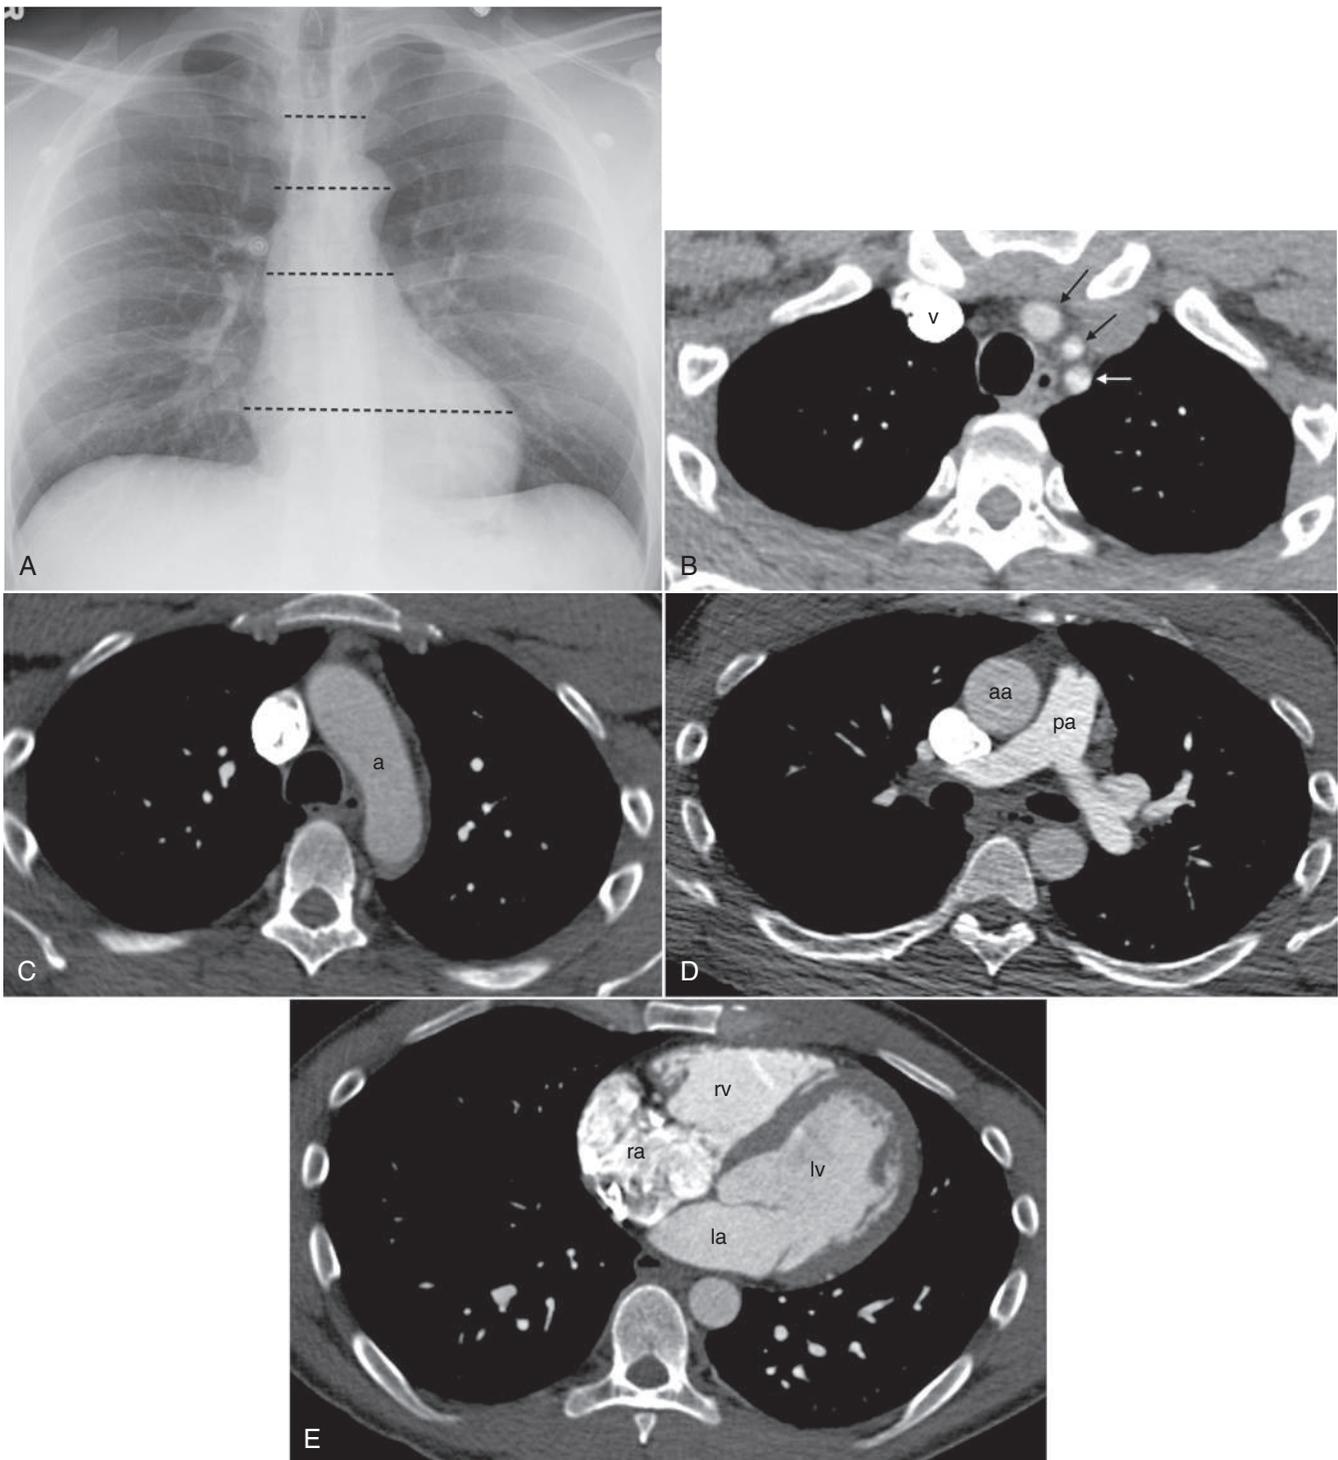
A, Posteroanterior chest radiograph indicating the four levels at which computed tomography scan slices B to E were obtained. B, The most superior image is at the level of the great vessels. Contrast material fills the right brachiocephalic vein (*v*) and the three arch vessels, the right brachiocephalic, left common carotid, and left subclavian arteries. C, At this level, the arch of the aorta (*a*) lies on the left side of the airway. The esophagus is seen in front of the vertebral body behind the airway. The opacified superior vena cava lies to the right of the arch anteriorly. D, At the level of the pulmonary artery bifurcation, the right pulmonary artery crosses the mediastinum anterior to the right main bronchus. The vena cava lies to the right of the ascending aorta (*aa*). The descending aorta is seen next to the vertebral body. E, At the level of the heart, contrast material is seen filling the right atrium (*ra*) and crossing the atrioventricular (tricuspid) valve into the right ventricle (*rv*). The thick, muscular left ventricular (*lv*) wall is visualized as it contracts. The left atrium (*la*) is seen anterior to the esophagus.
